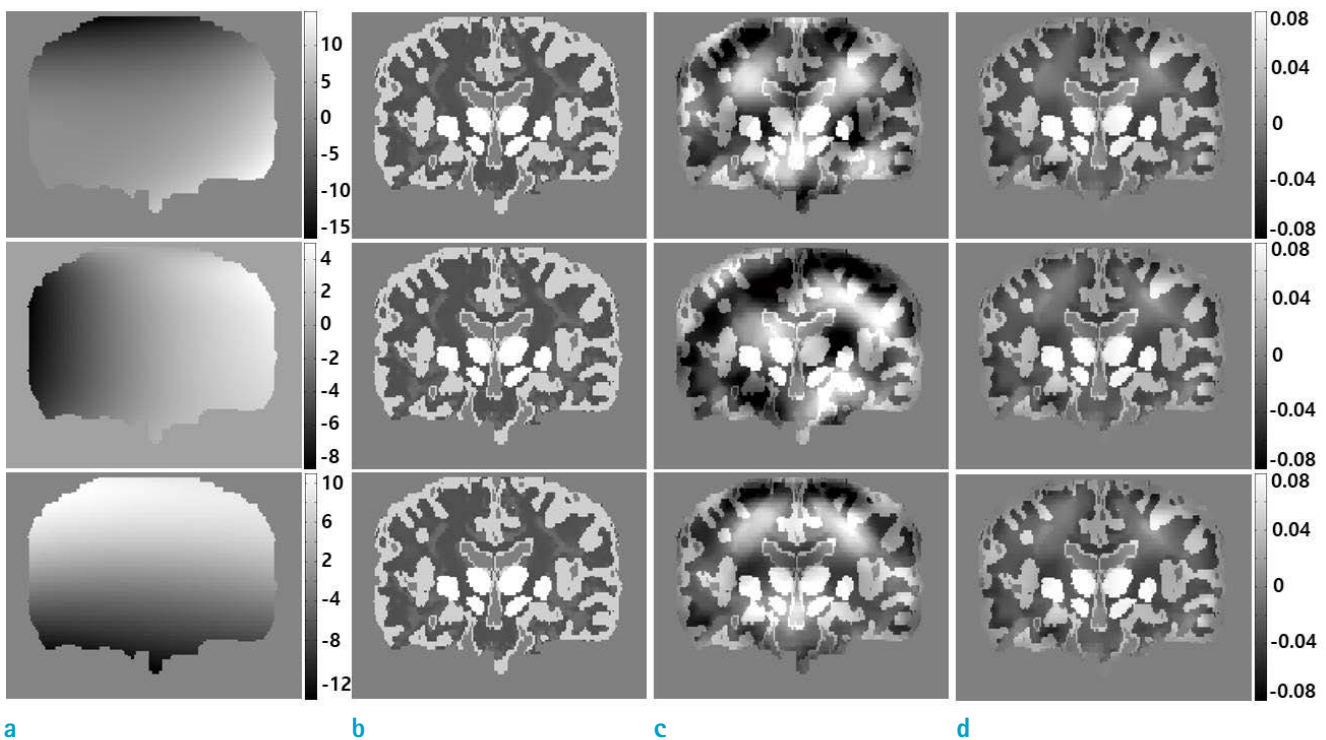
Susceptibility maps are shown under the three inhomogeneity types: (a) global inhomogeneity phase, (b) true susceptibility maps, (c) susceptibility maps obtained without global inhomogeneity correction, and (d) susceptibility maps obtained with the global inhomogeneity correction by SUPER. The global inhomogeneity is modeled from a 3.0T MRI, a 7.0T MRI, and a non-physical model, from top to bottom.
